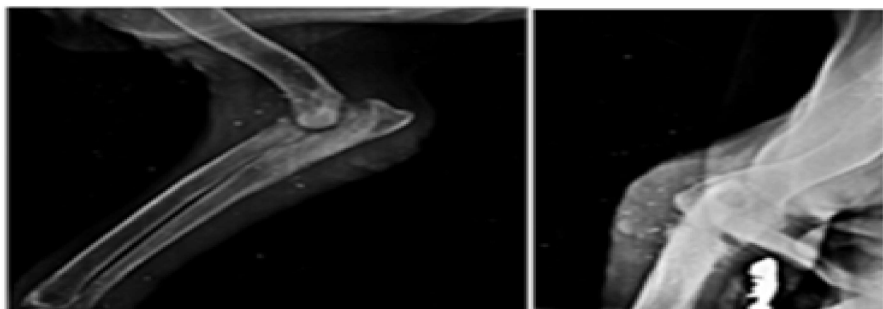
Post operative radiograph after 6 month
